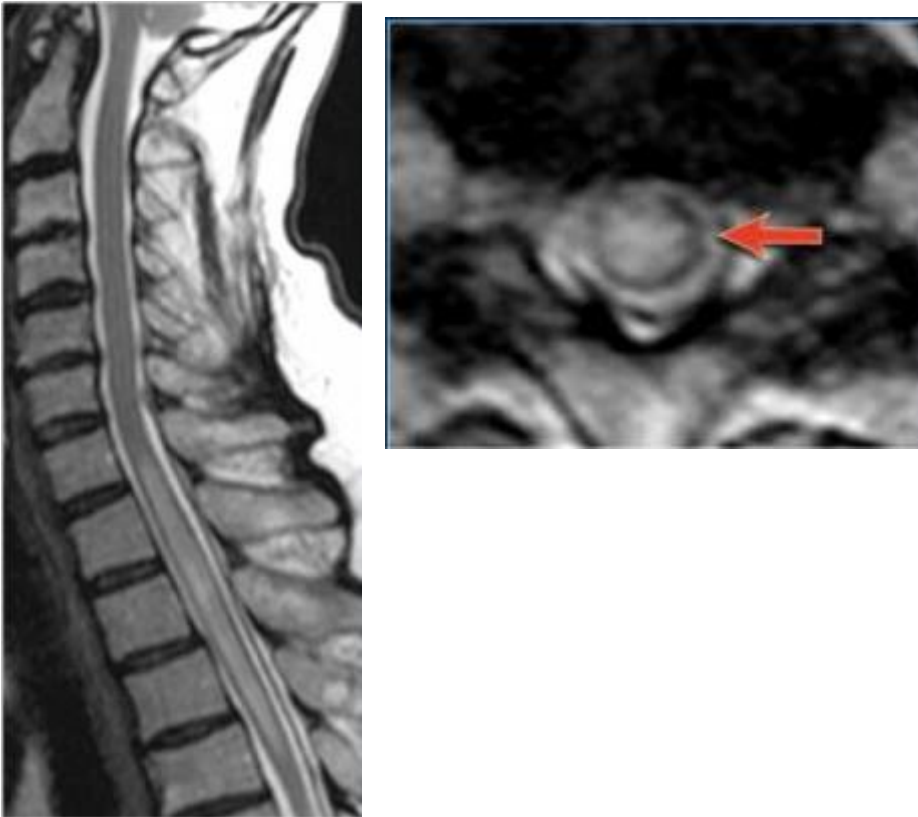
T2-WI sagittal MRI of cervical spine demonstrate extending from lower-C6 to mid-D3 (between arrows) and mildly expanding the cord (a). (b). On an axial T2-weighted image at the D1 level most of the cord is involved and shows a hyperintense signal suggesting TM
